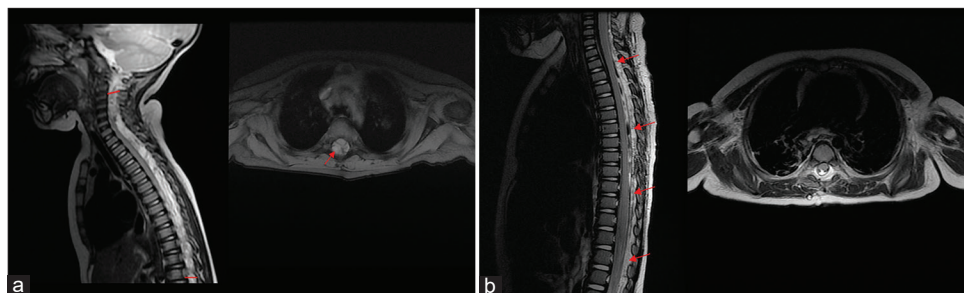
Preoperative holo-spine magnetic resonance imaging showing a large cervicothoracic posterior epidural hematoma, hyperintense in T2-weighted images (a, red arrow in axial plane) and hypointense in T1-weighted images (b, red arrows in sagittal plane).
